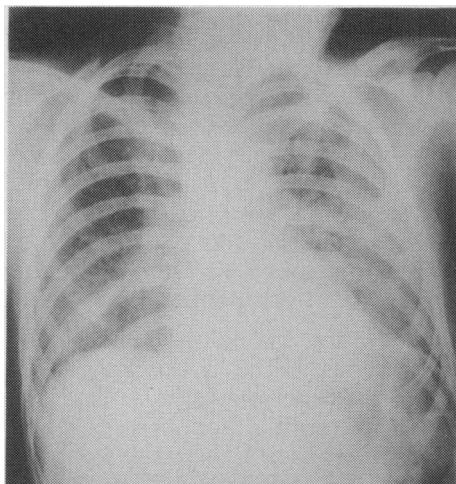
Chest X-ray showing areas of consolidation consistent with an atypical pneumonia 2 days before death.
